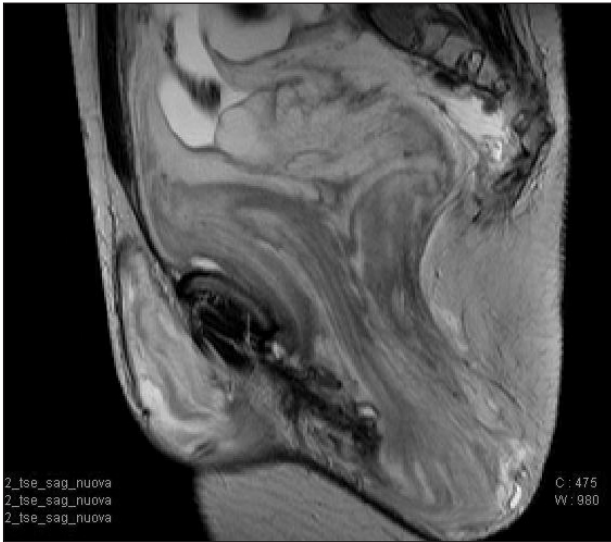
Pelvic tumor hyperintense in T2-weighted images with a swirled internal structure and presenting non-homogeneous enhancement.
